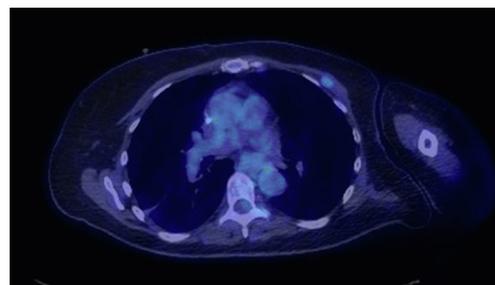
Axial slice of a PET/CT scan demonstrating a hypermetabolic isolated left chest wall recurrence dorsal to the pectoralis major muscle.
